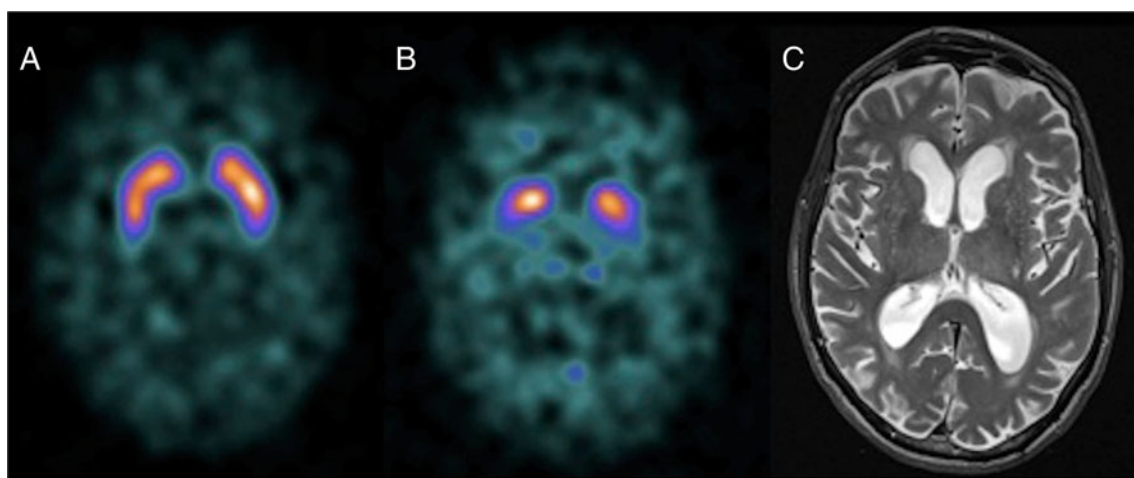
Normal DAT scan (a) for comparison. DAT scan of a patient with DLB (b) showing lack of tracer uptake in the putamen bilaterally. Axial T2-weighted image (c) of the same patient shows non-specific generalised supratentorial volume loss
